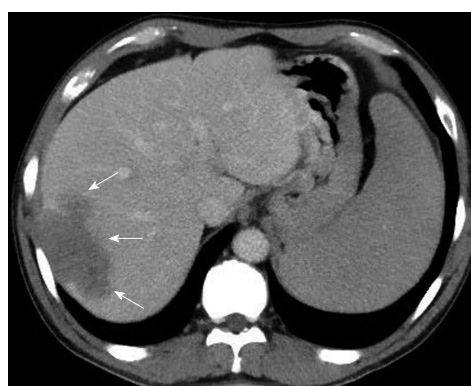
Computed tomography later showed wash out during the delay phase; this is compatible with hepatocellular carcinoma (arrows) with chest wall involvement. No obvious imaging evidence of liver cirrhosis and portal hypertension was shown.
